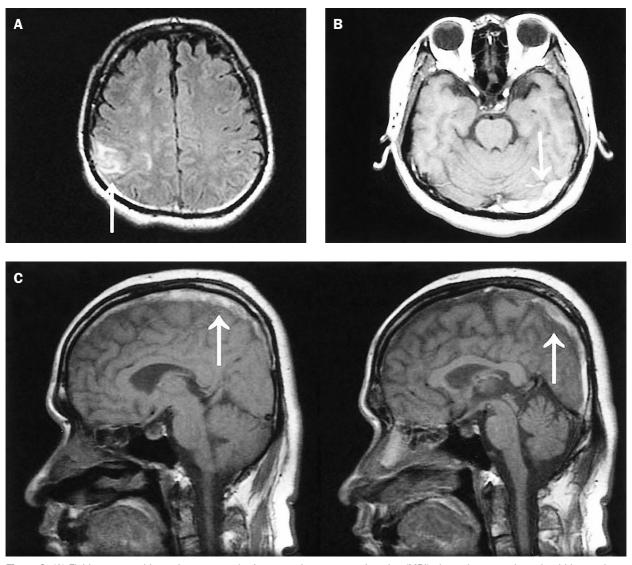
(A) Fluid attenuated inversion recovery brain magnetic resonance imaging (MRI) showed acute subarachnoid hemorrhage over the right parietal sulci (arrow). (B) Left transverse sinus thrombus was shown on T1-weighted MRI with contrast injection (arrow). (C) Superior sagittal sinus thrombus demonstrated on T1-weighted MRI with contrast injection (arrows).
